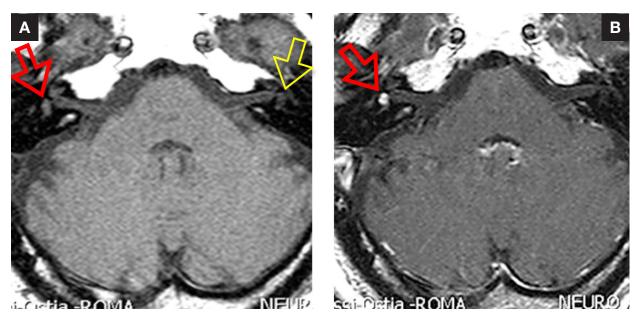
A: T1-weighted spin-echo axial MRI without contrast shows the area of altered signal in the right labyrinth. The pathologic tissue (red arrow) was slightly more intense than the endo-perilymphatic fluid on the contralateral side (yellow arrow). B: With contrast, the image shows that the heterogeneously enhancing intravestibular hypervascularized mass is contiguous to the falciform crest with no signs of extension into the internal auditory canal (arrow).
